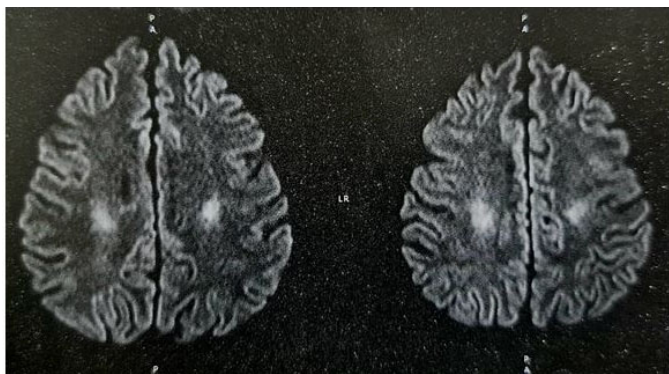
Brain MRI—axial view—The hyperintense signal on FLAIR compromises the periventricular white matter, which may correspond to a decrease in myelin.
